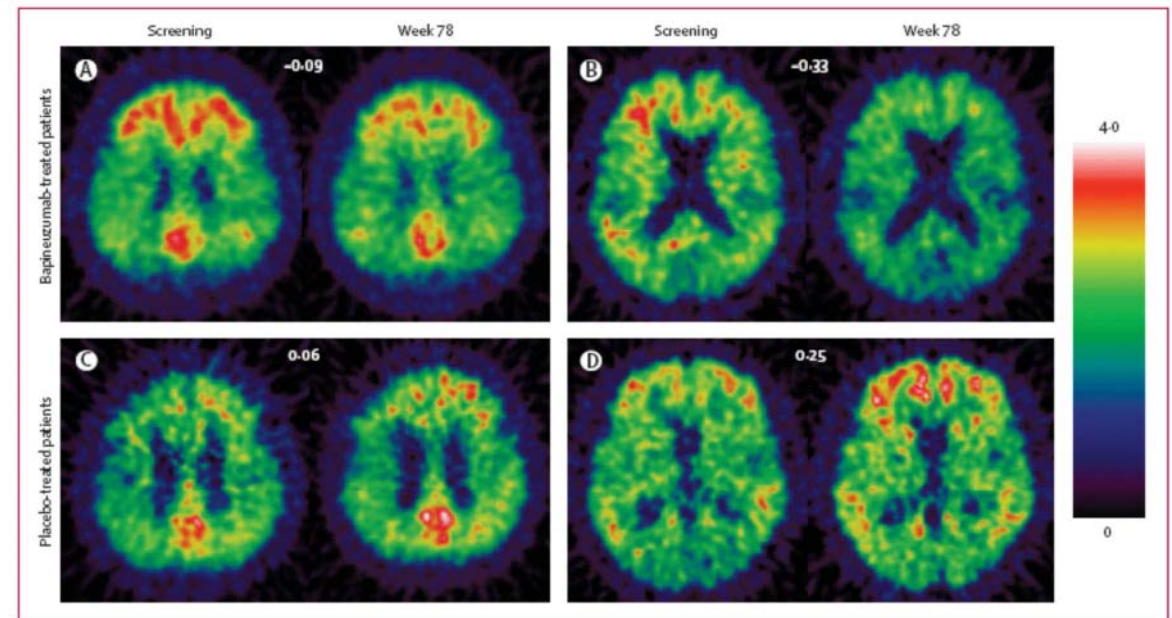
^{11}C -PIB PET images from patients treated with bapineuzumab and those given placebo. Changes from screening to week 78 in patients treated with bapineuzumab (A, B) and in patients treated with placebo (C, D). Mean ^{11}C -PIB PET changes are shown at the top centre of each panel for each patient. The scale bar shows the PIB uptake ratios relative to cerebellum by colour. The scans before and after treatment are from MRI co-registered images in the same plane. PIB=Pittsburgh compound B.
